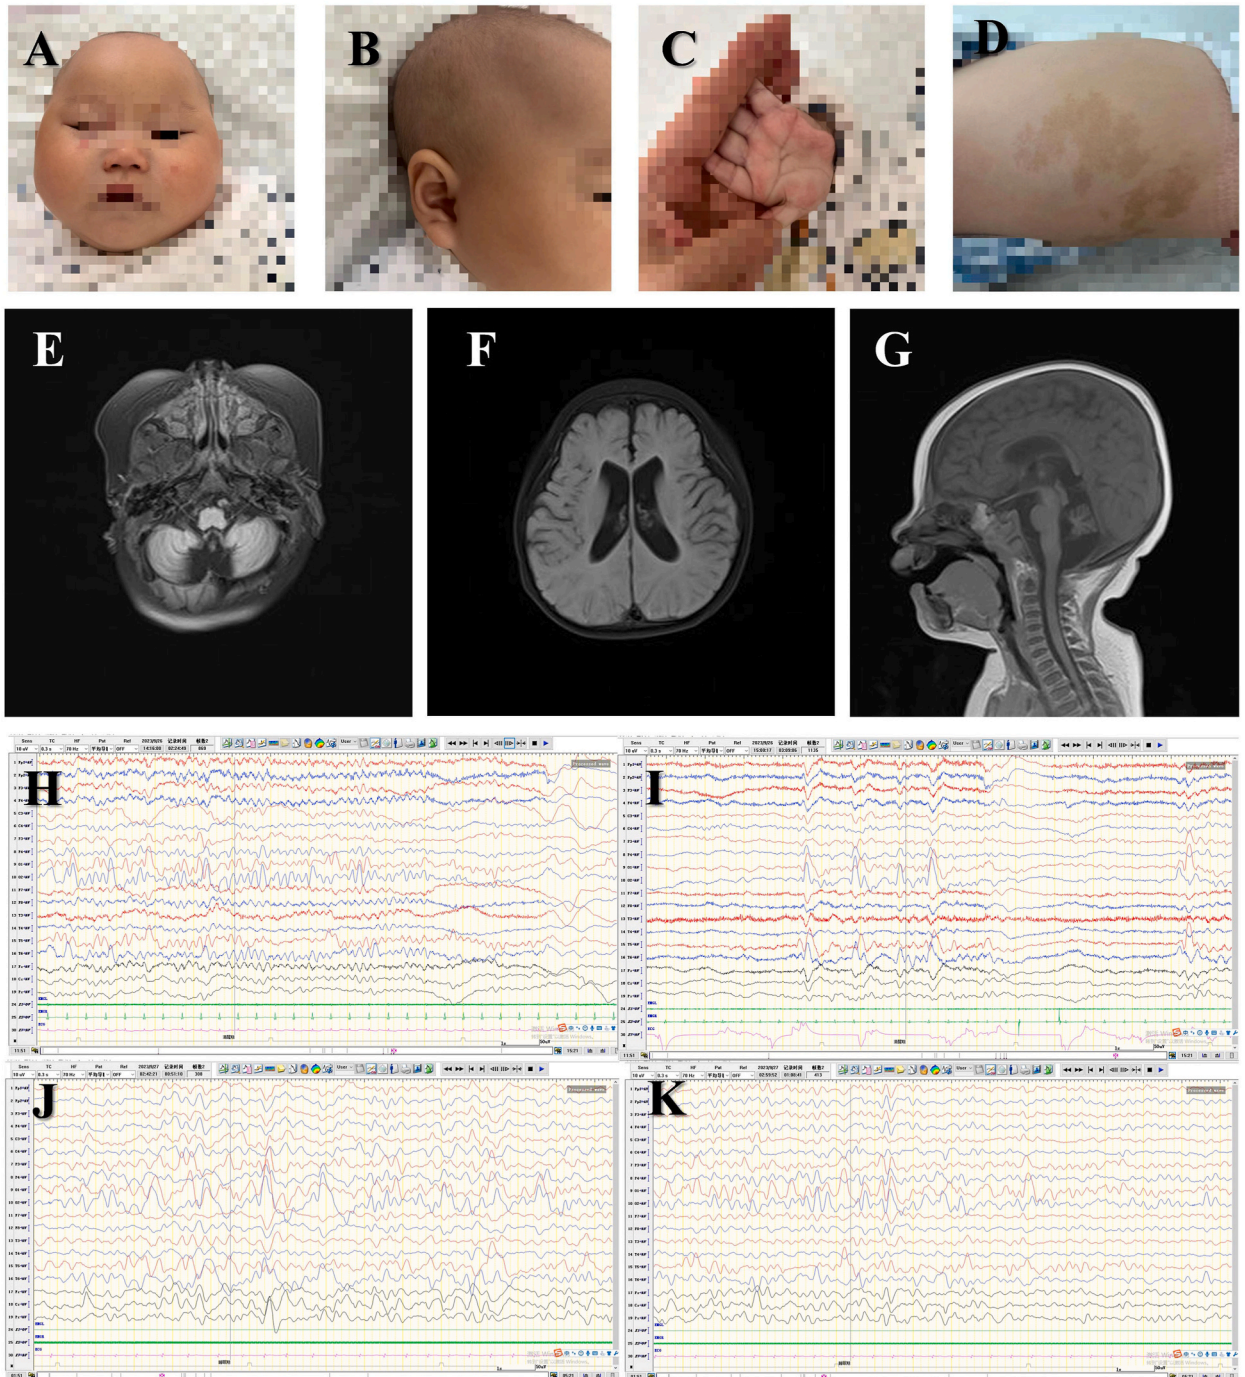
A. Narrow forehead, upward-slanting corners of the eyes bilaterally and collapsed nose. B. Large ears. C. A hand through the palm. D. A large area of coffee-milk spot. MRI of the patient (6 months, E-G). E. T2-weighted imaging (T2WI): slightly smaller volume of bilateral cerebellar hemispheres. F. T2WI: slightly smaller volume of bilateral frontal lobes and slightly wider lateral ventricles. G. T1WI: a thinner body of corpus callosum and knees. Video Electroencephalograph (13 months, H-K). A large number of medium-high amplitude slow waves emanating, paroxysmal or continuous in the parietal, occipital, posterior temporal and midline regions in all phases of wakefulness and sleep, and non-synchronous in the left and right.
